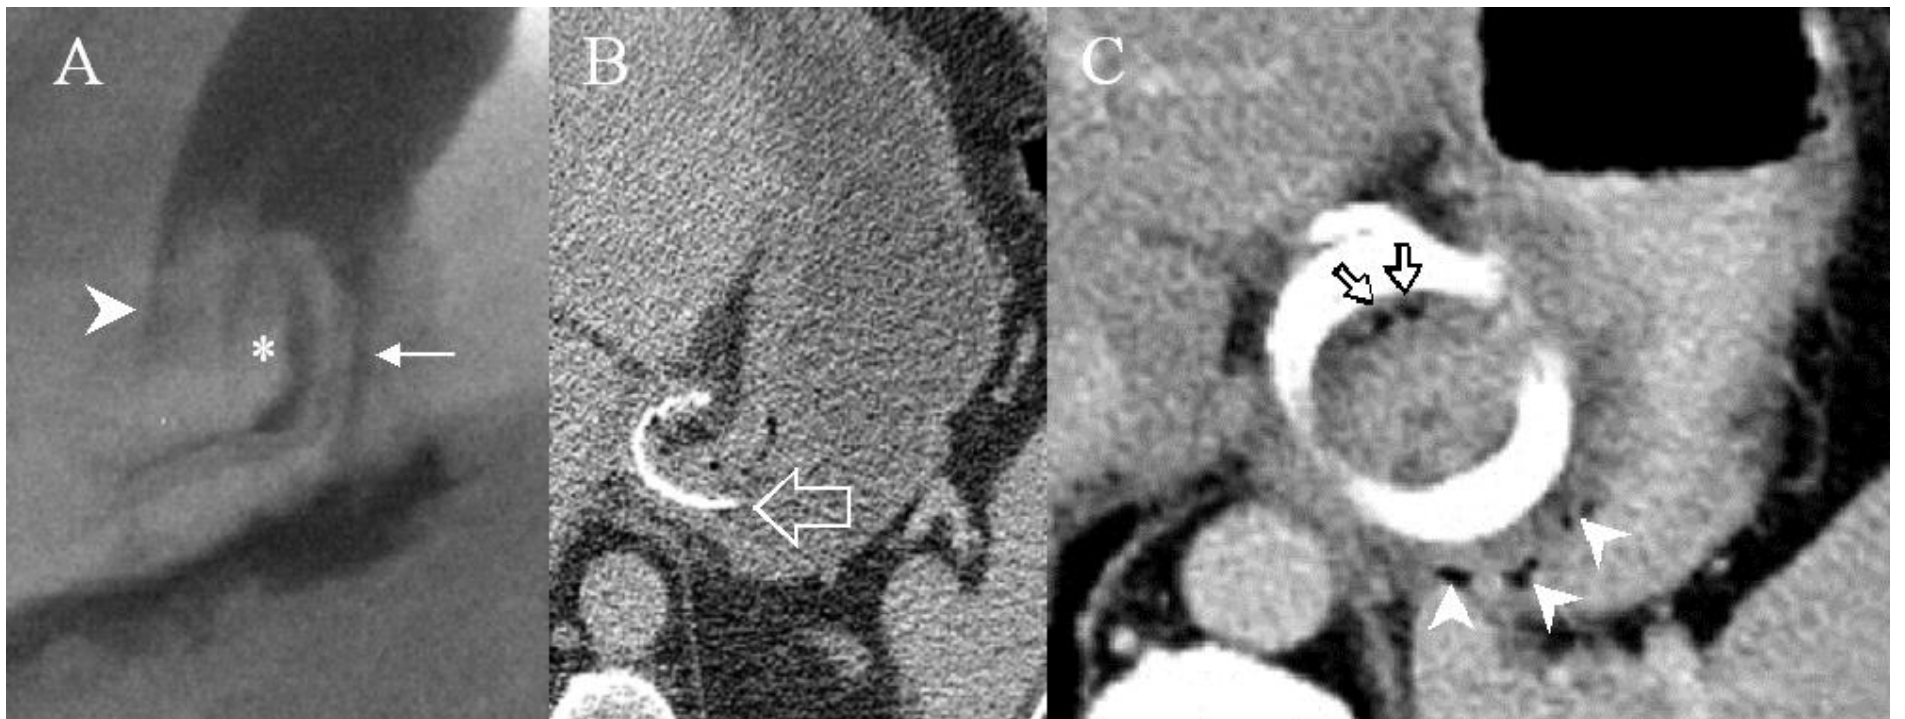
Patient with symptoms of mild dysphagia investigated for possible band slip. Lateral view (Panel A) during water-soluble contrast swallow demonstrating contrast passing behind (line arrow) the posterior aspect of the band (asterisk). Very little contrast passes through the band stoma (arrow-head). Axial CT in the same patient (Panel B) demonstrates the band within lumen of stomach (open arrow). Panel C: Second patient with band infection following surgery outside the UK presenting at 3 months. Axial CT demonstrates extramural locules of gas anteriorly (open arrows) with erosion into the posterior stomach (arrowheads). There was no response to antibiotics and the LABG was removed.
